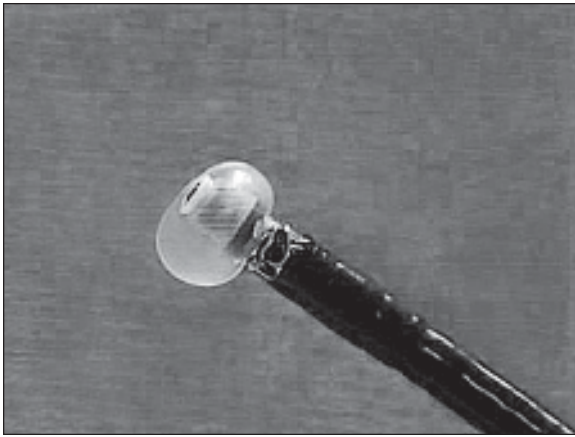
Endoscopic ultrasound with water-filled balloon at the tip
